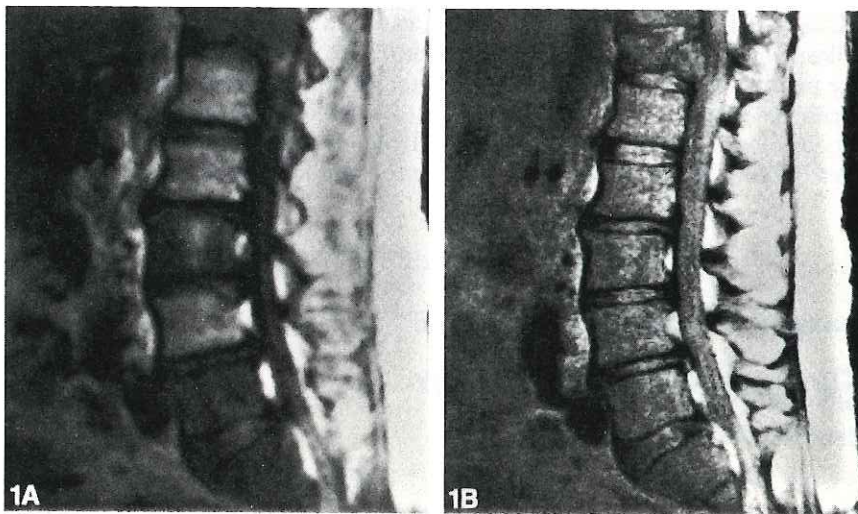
T1-weighted sagittal (A) and proton density-weighted (B) images of lumbar spine. Focal marrow lesions involving multiple vertebral bodies evident on A are not apparent on B. (Courtesy of L. Solti-Bohman)
